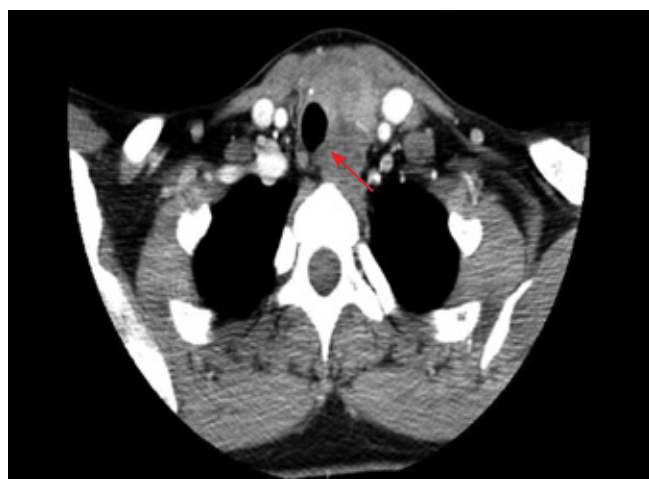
Computed tomography (CT) scan showing the extent of the thyroid carcinoma. The red arrow indicates tracheal and esophageal invasion.
